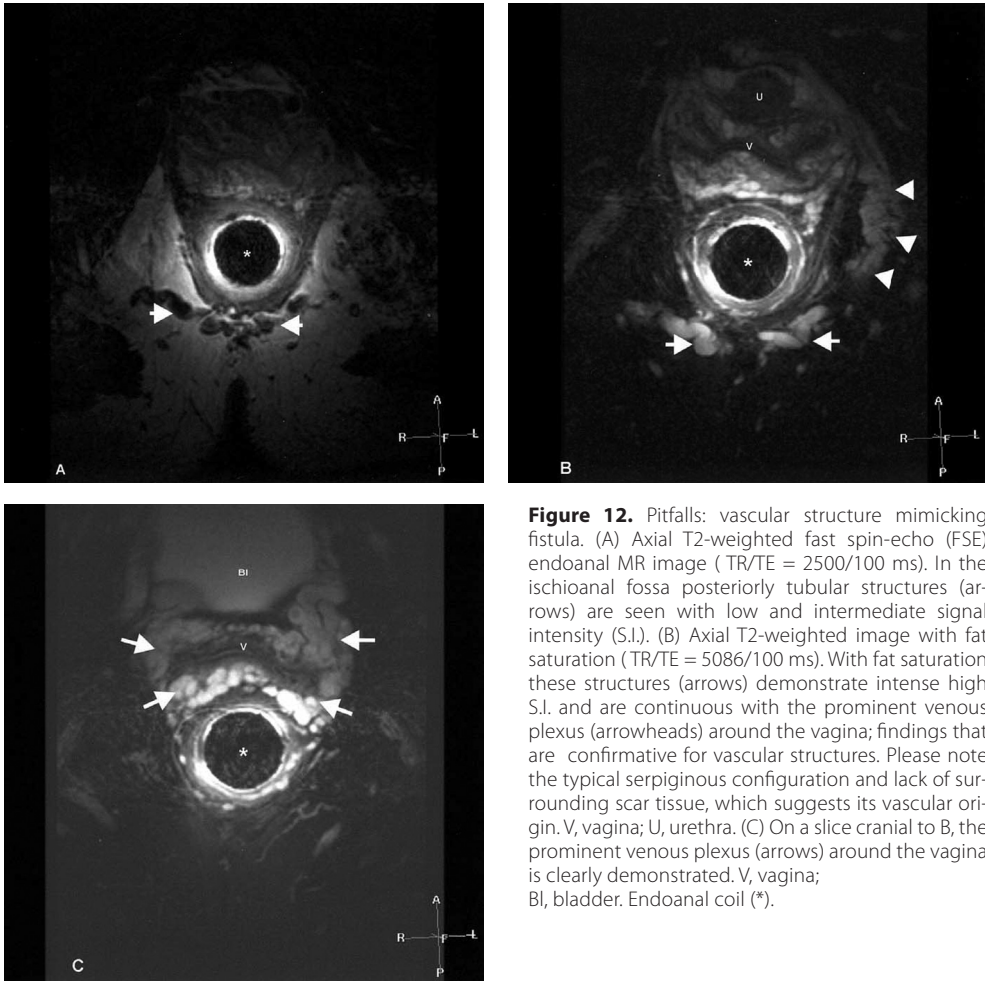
Pitfalls: vascular structure mimicking fistula. (A) Axial T2-weighted fast spin-echo (FSE) endoanal MR image (TR/TE = 2500/100 ms). In the ischioanal fossa posteriorly tubular structures (arrows) are seen with low and intermediate signal intensity (S.I.). (B) Axial T2-weighted image with fat saturation (TR/TE = 5086/100 ms). With fat saturation these structures (arrows) demonstrate intense high S.I. and are continuous with the prominent venous plexus (arrowheads) around the vagina; findings that are confirmative for vascular structures. Please note the typical serpiginous configuration and lack of surrounding scar tissue, which suggests its vascular origin. V, vagina; U, urethra. (C) On a slice cranial to B, the prominent venous plexus (arrows) around the vagina is clearly demonstrated. V, vagina; Bl, bladder. Endoanal coil (*).
